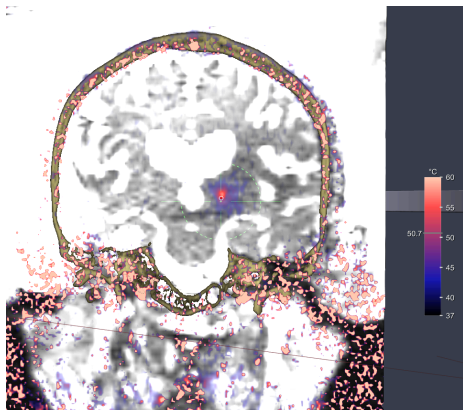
Ultrasound treatment data loaded into Kranion, showing thermometry data
